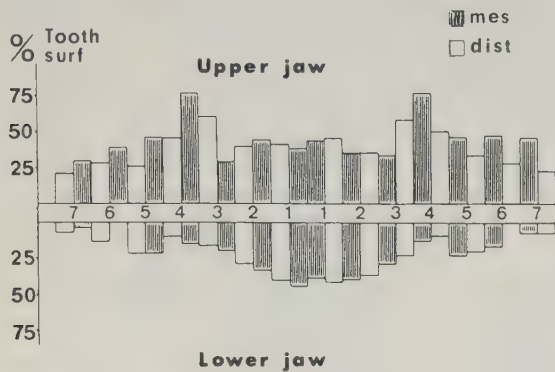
The distribution of non-measurable boneheights as found in orthopantomographs of 74 dentate women.
